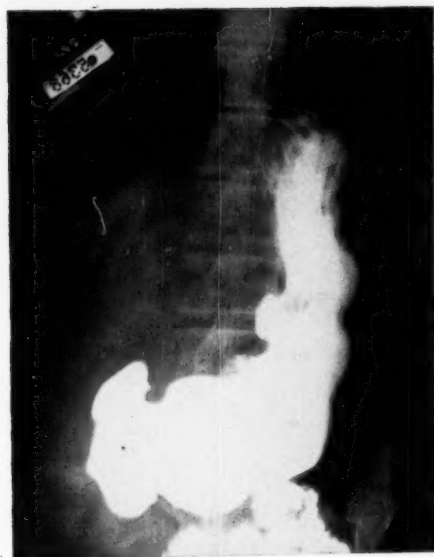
Roentgenogram of gastric ulcer four weeks after medical treatment, indicating marked decrease in size of original crater.
